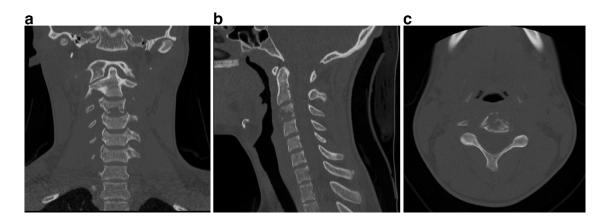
CT scan without contrast with coronal (A), sagittal (B), and axial (C) views showing a lytic destructive lesion involving the C3 vertebral body with cortical disruption and a prevertebral soft tissue component.
